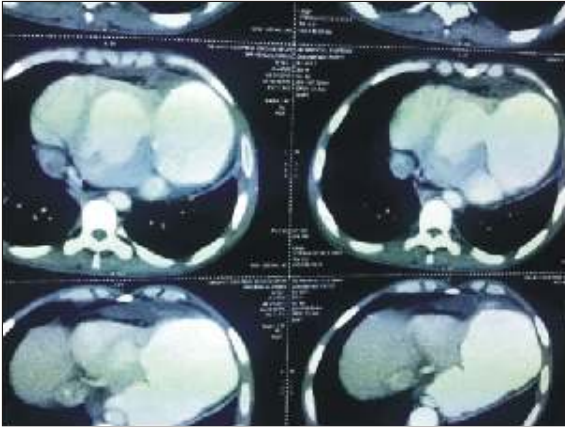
Multislice Cardiac CT showing the large out pouching and the communication between two cavities
